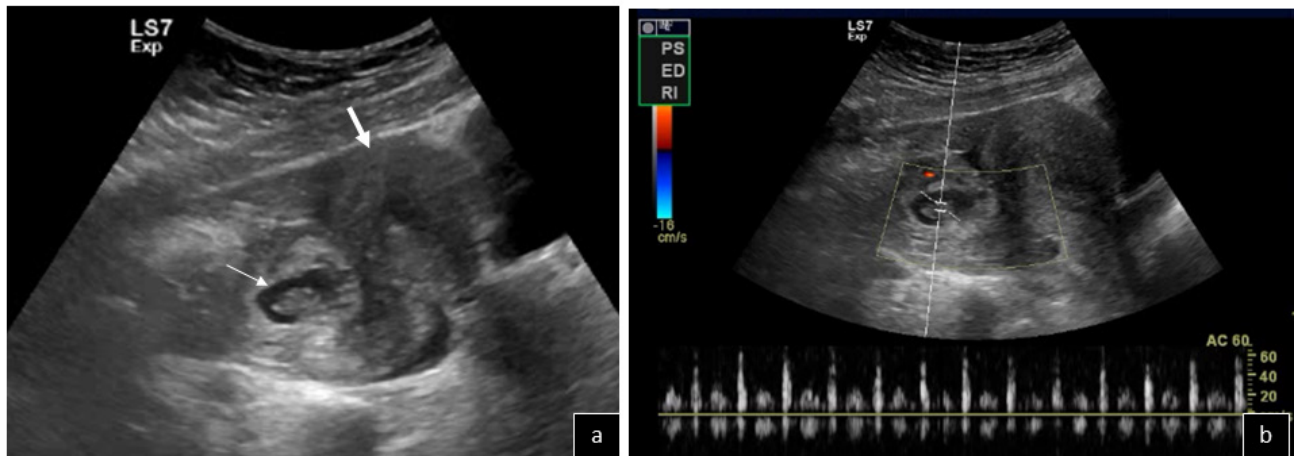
Extrauterine pregnancy: A gestation sac (thin arrow) is noted outside of the uterus (thick arrow) on B-mode US (a). Fluid is also seen. Foetal cardiac function is present on spectral Doppler US (b).
